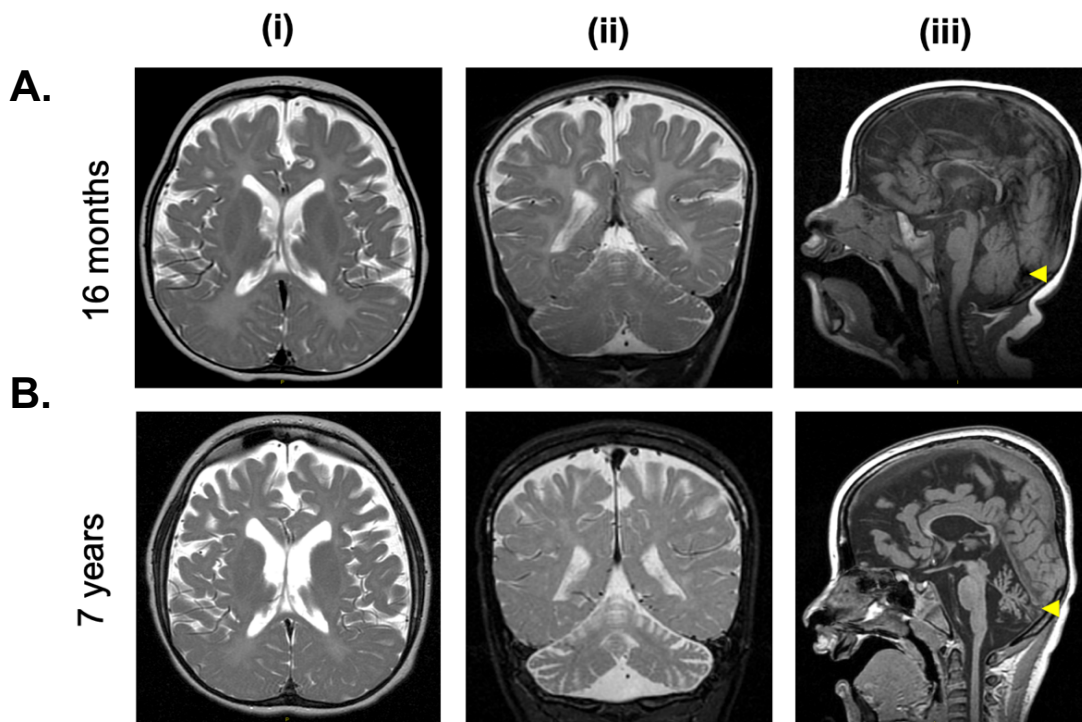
Patient T2- FLAIR MRI sequences reveal hypomyelination and cerebral and cerebellar atrophy.
